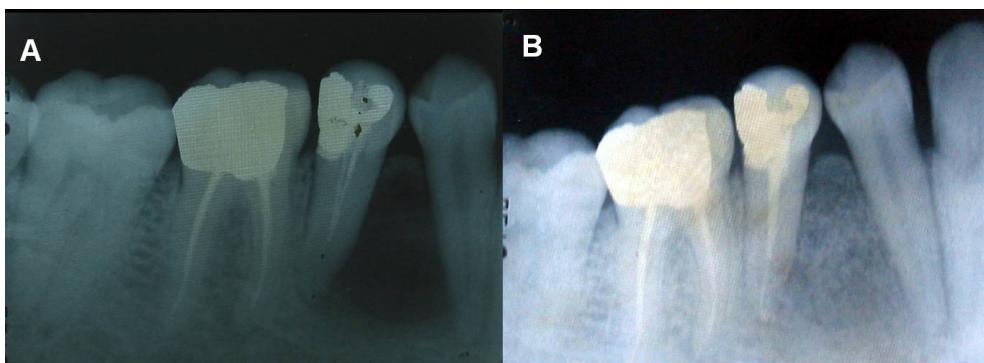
Periapical view of lateral periodontal cyst A. Pre-treatment B. Post-treatment
